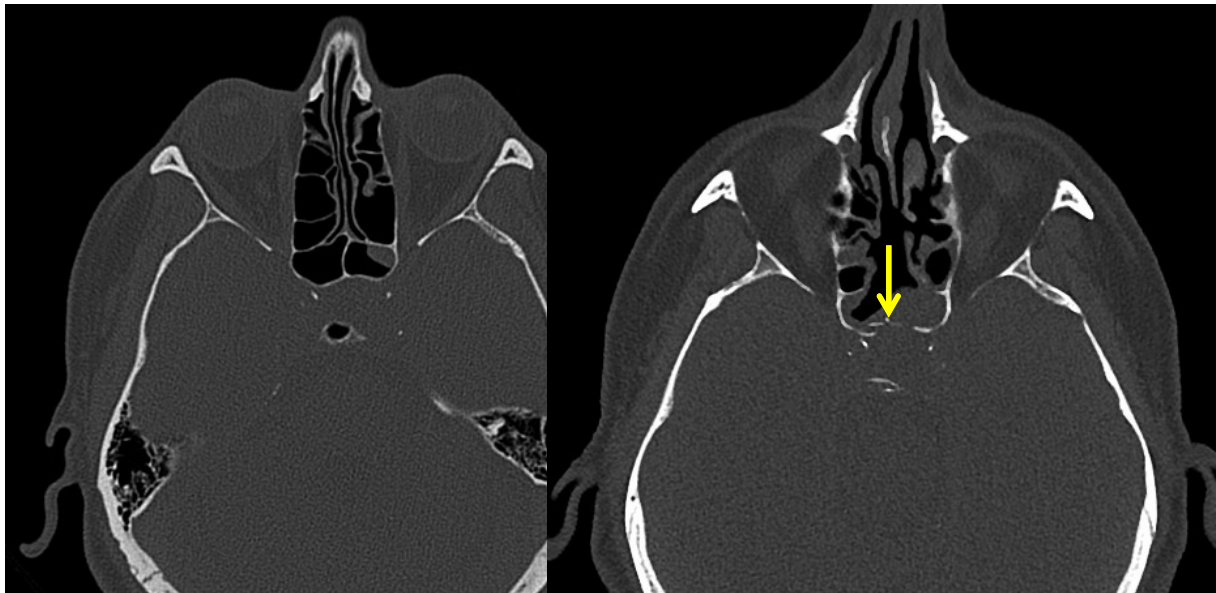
Pre- (left) and postoperative (right) CT scan (axial plane) showing that the bone flap partially healed in after 3 months (yellow arrow).
